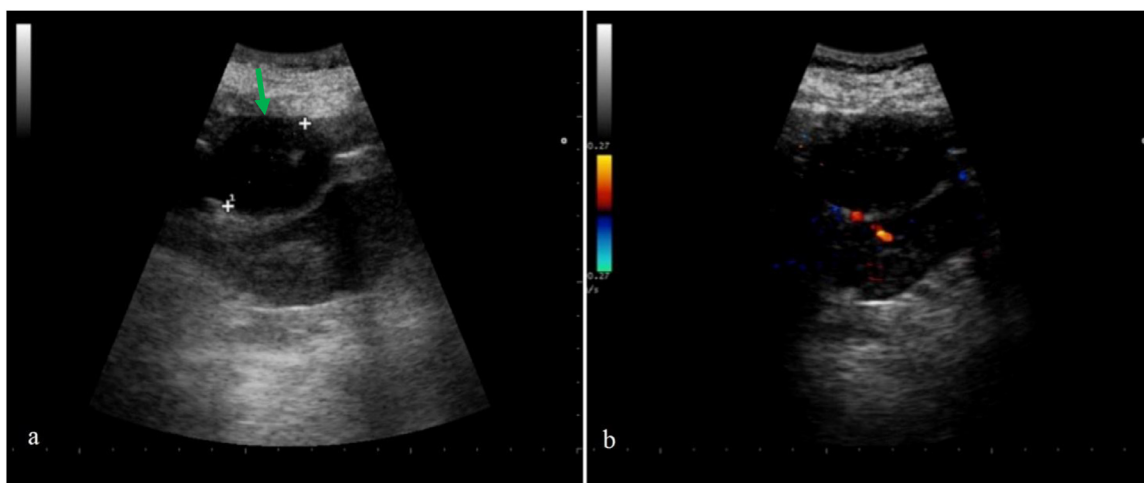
(A) US 1 month later shows inhomogeneous ipoechoic accessory spleen (green arrow); (B) no blood sign at color-Doppler. (Color version of figure is available online).
